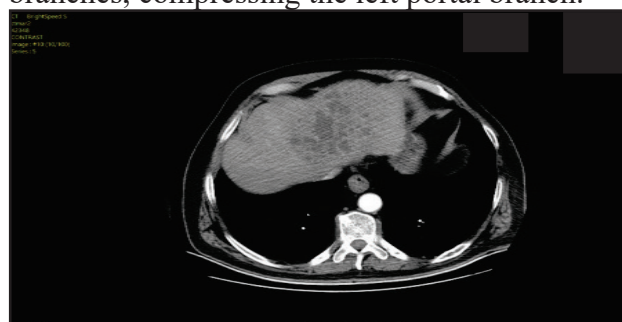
CT-scan of the liver abscess
